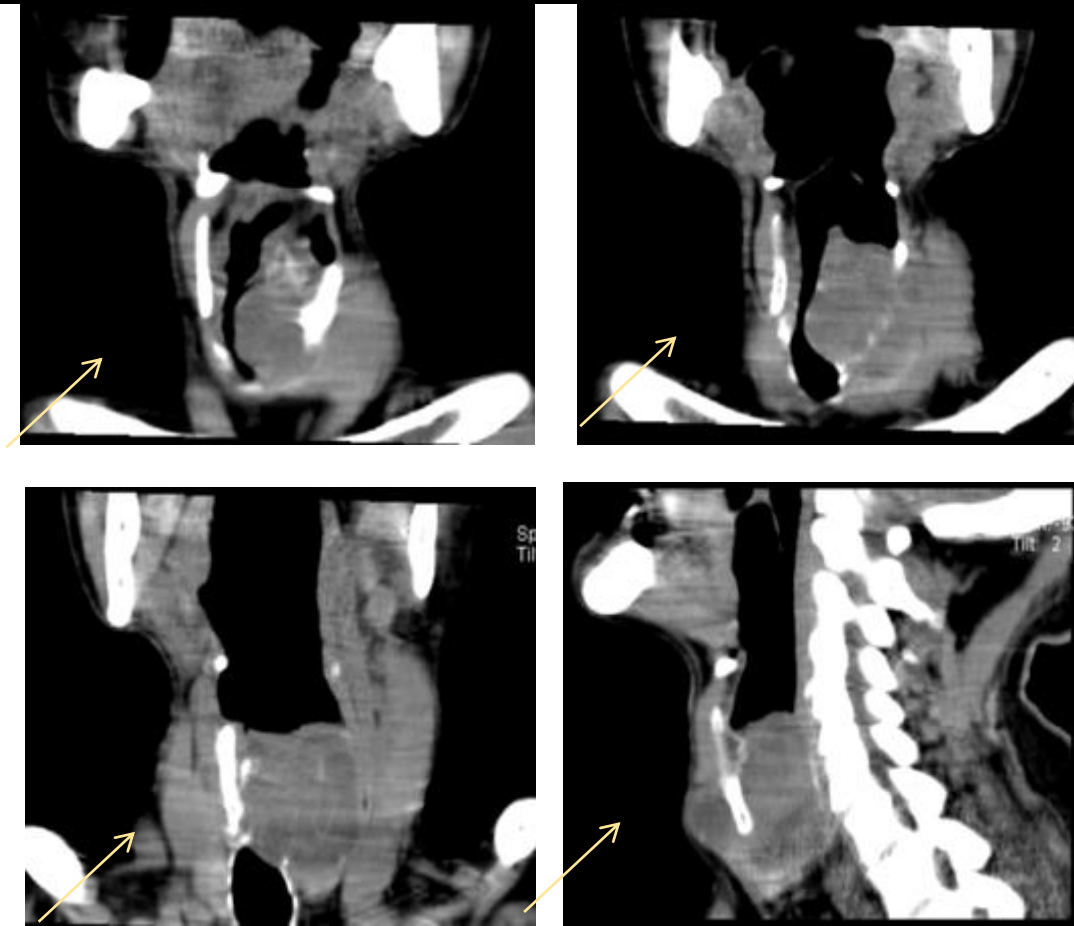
The patient's neck CT scan includes both a frontal and sagittal projection. In the larynx projection, a volumetric formation with dimensions of up to 4.8x4.8x4.1 cm, +33+46 HU, and a heterogeneous structure is identified.
